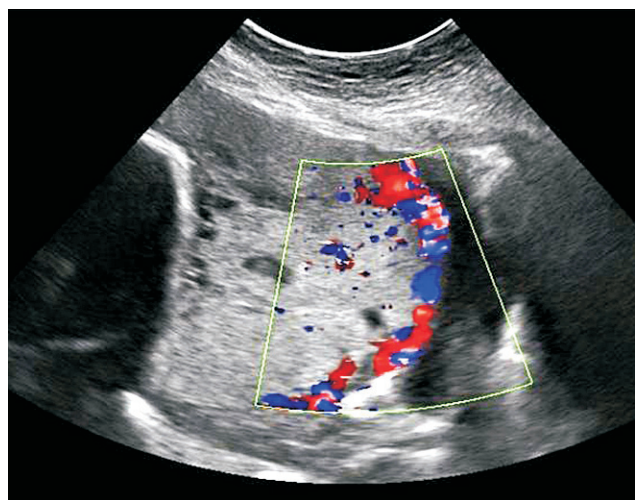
Three-dimensional color Doppler image showing placenta accreta
